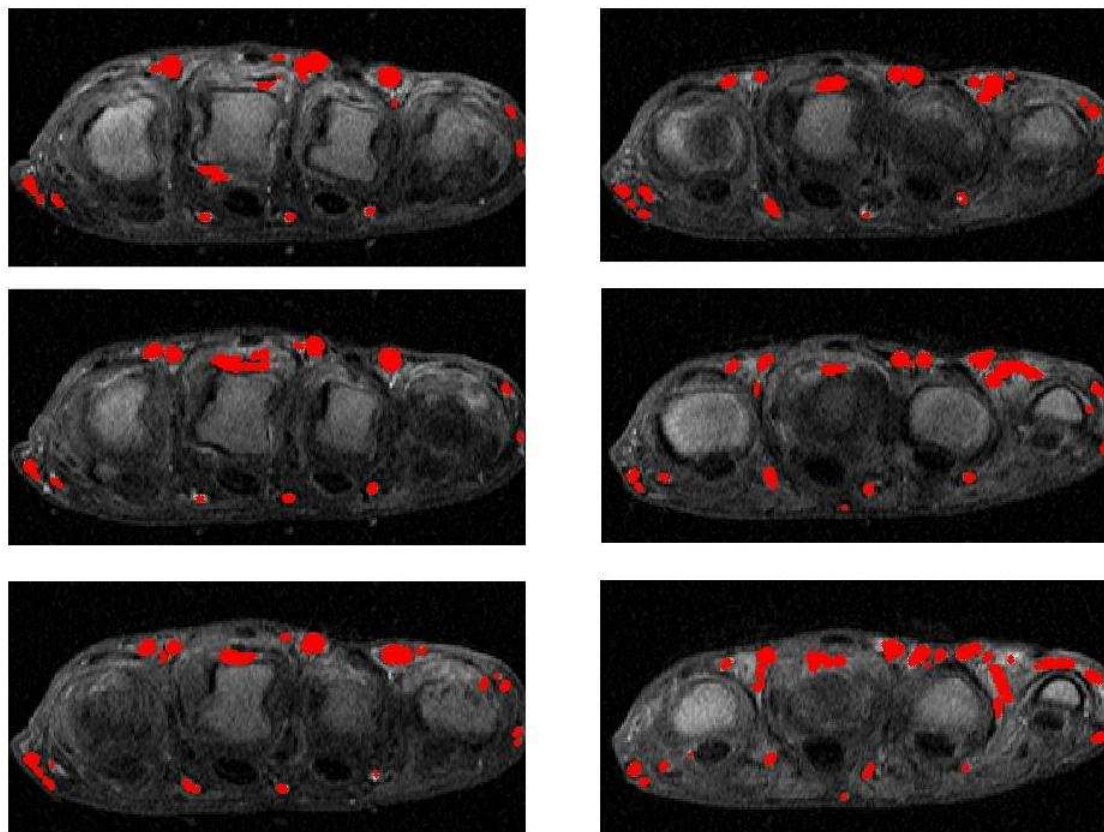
Six post-contrast images from different DCE-MRI slices; pixels classified as vessels are shown in red.
